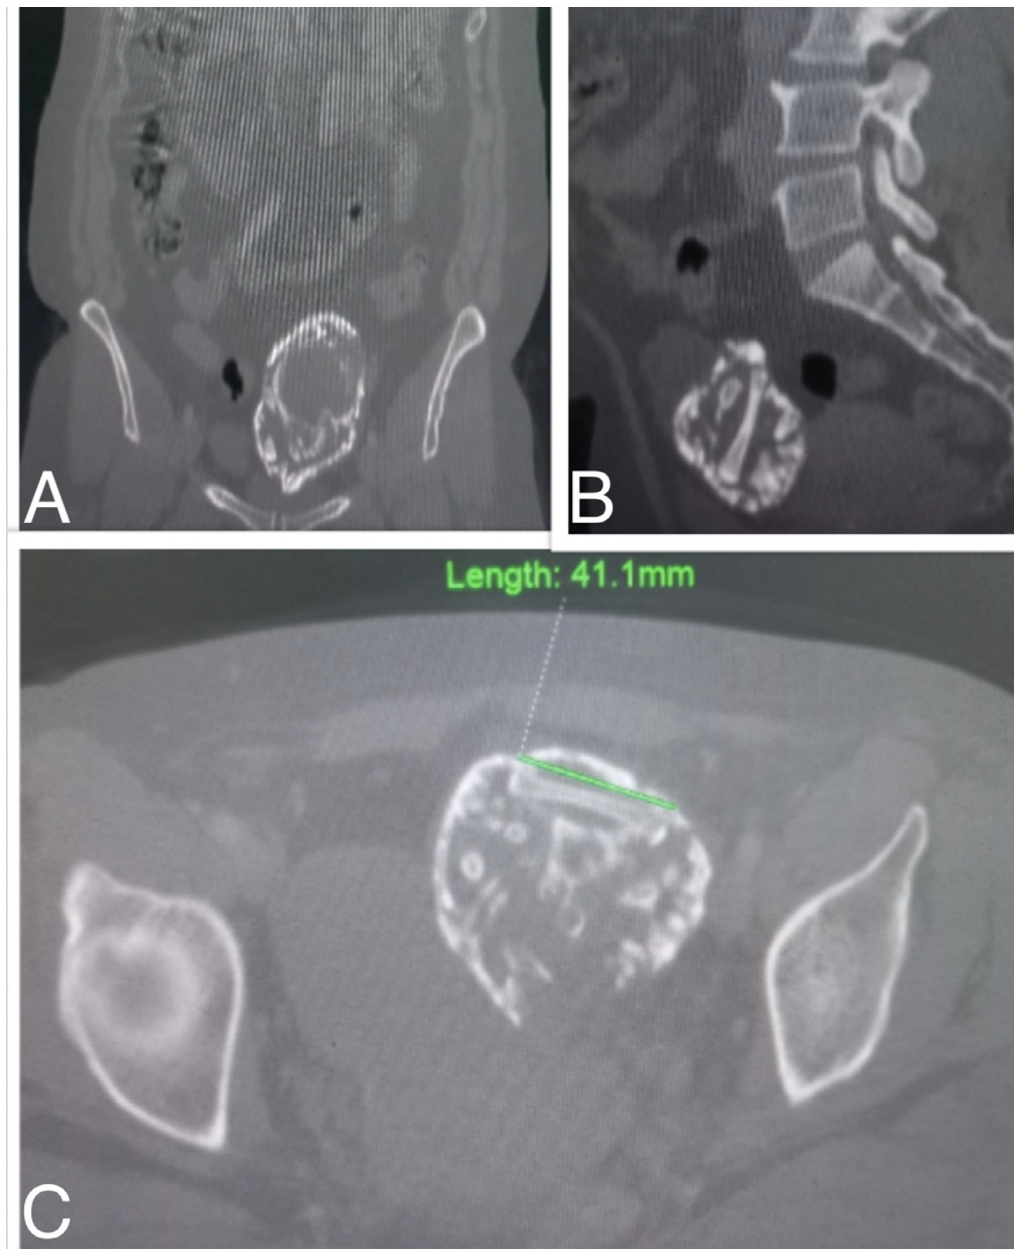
Bone window of abdominal CT, coronal (A) sagittal (B), and axial (C). Bone window CT reconstructions reveal details of fetal anatomy with calcified shell, fetal head and femur. The femur measured at 4.1 cm thus estimating the age of the fetus at about 23 weeks of amenorrhea.
